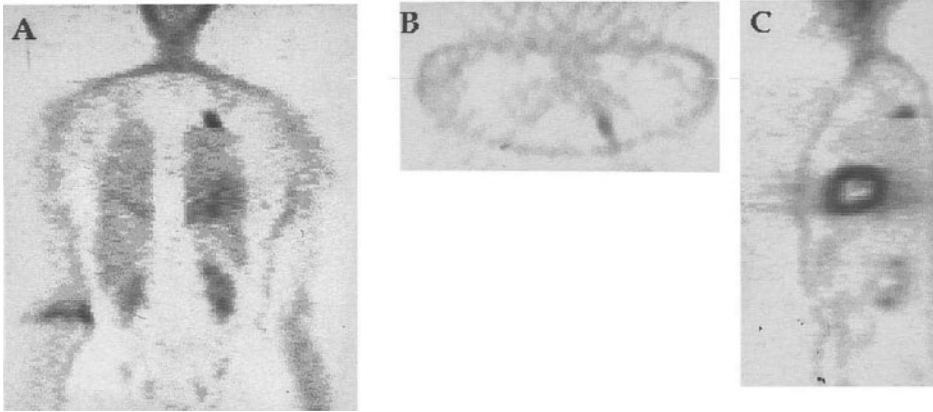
$A^{18}F$ FDG scan in a patient with left upper lobe opacity and suspicious cells on needle aspiration. The lesion has a high uptake on FDG uptake seen on the coronal (A), transaxial (B) and the sagittal (C) cuts, despite the high uptake this was not a carcinoma but was shown to be *mycobacterium tuberculosis*.
